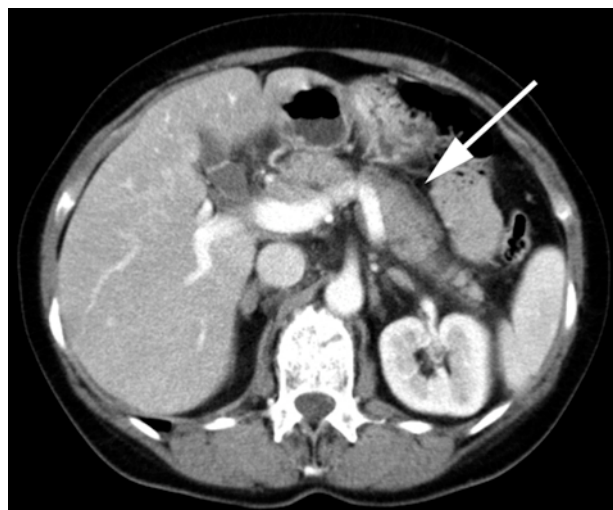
Abdominal CT scan showing signs of exsudative pancreatitis with diffuse enlargement and irregular contour of the pancreas as well as peripancreatic fluid collections (arrow).
